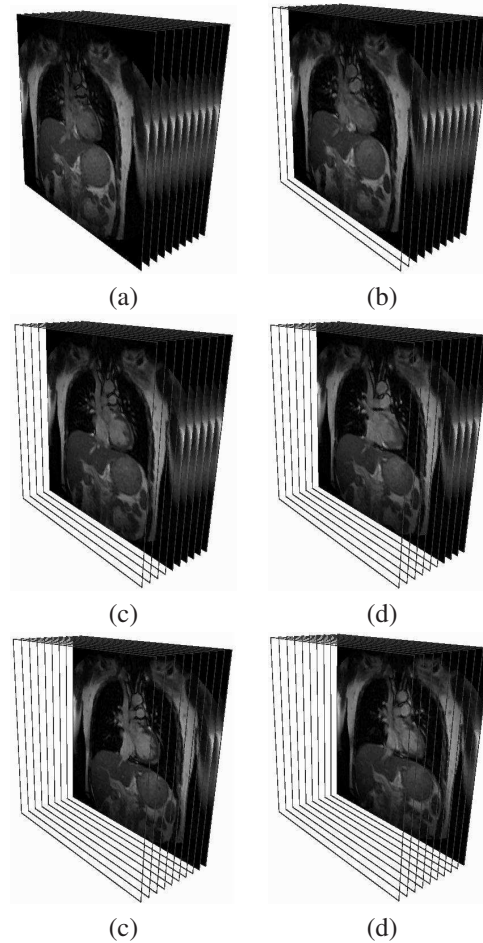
An example of one spatio-temporal volume (STV) builded from 10 MR images Im_{s,t_u} , ($u = 1, 2, 3, \dots, 9$) of a coronal slice s of the lung taken at time instants t_u . (a) STV with Im_{s,t_0} visible.(b) STV with Im_{s,t_2} visible.(c) STV with Im_{s,t_4} visible.(d) STV with Im_{s,t_6} visible.(e) STV with Im_{s,t_8} visible.(f) STV with Im_{s,t_9} visible.
